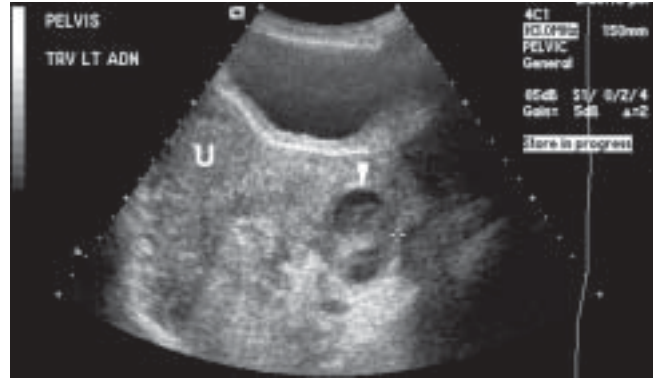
This transverse view of the pelvis by ultrasound further demonstrates the complex nature of the left ovary (arrow head) by highlighting its cavitory nature and its associated fluid-fluid levels. (U=uterus).
